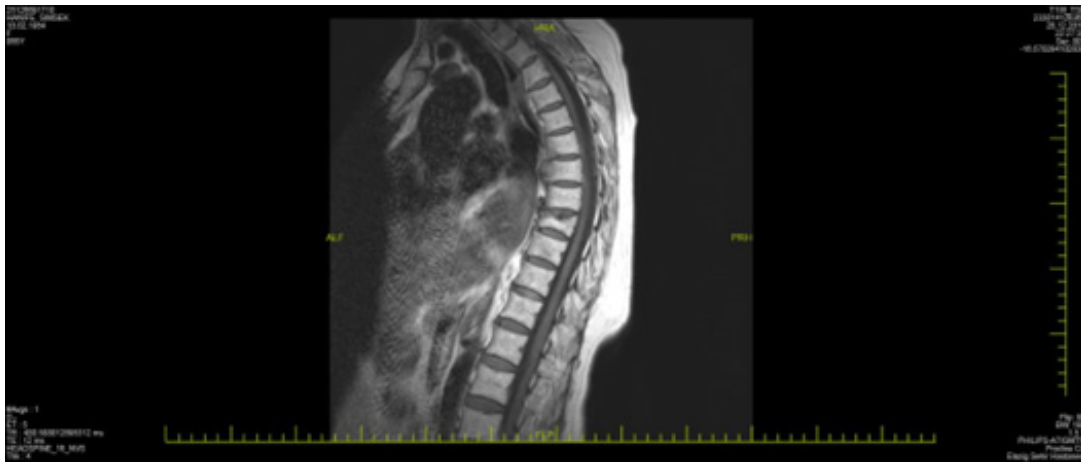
T9 vertebral compression fracture on T1 sequence MR image.
